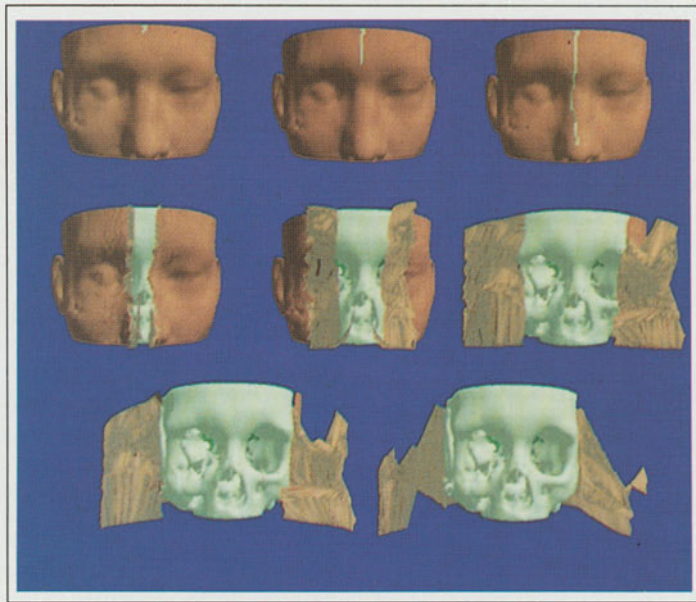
Skin, Skull and Brain from CT Data Set:
